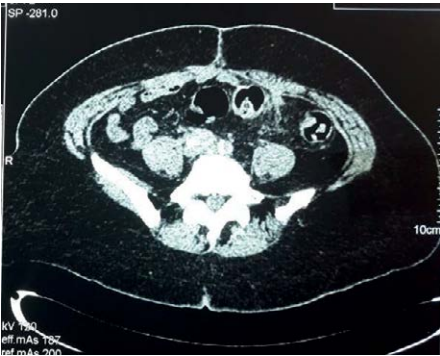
CT scan of abdomen after 1 year showing no evidence recurrent aneurysm / pseudo-aneurysm.
